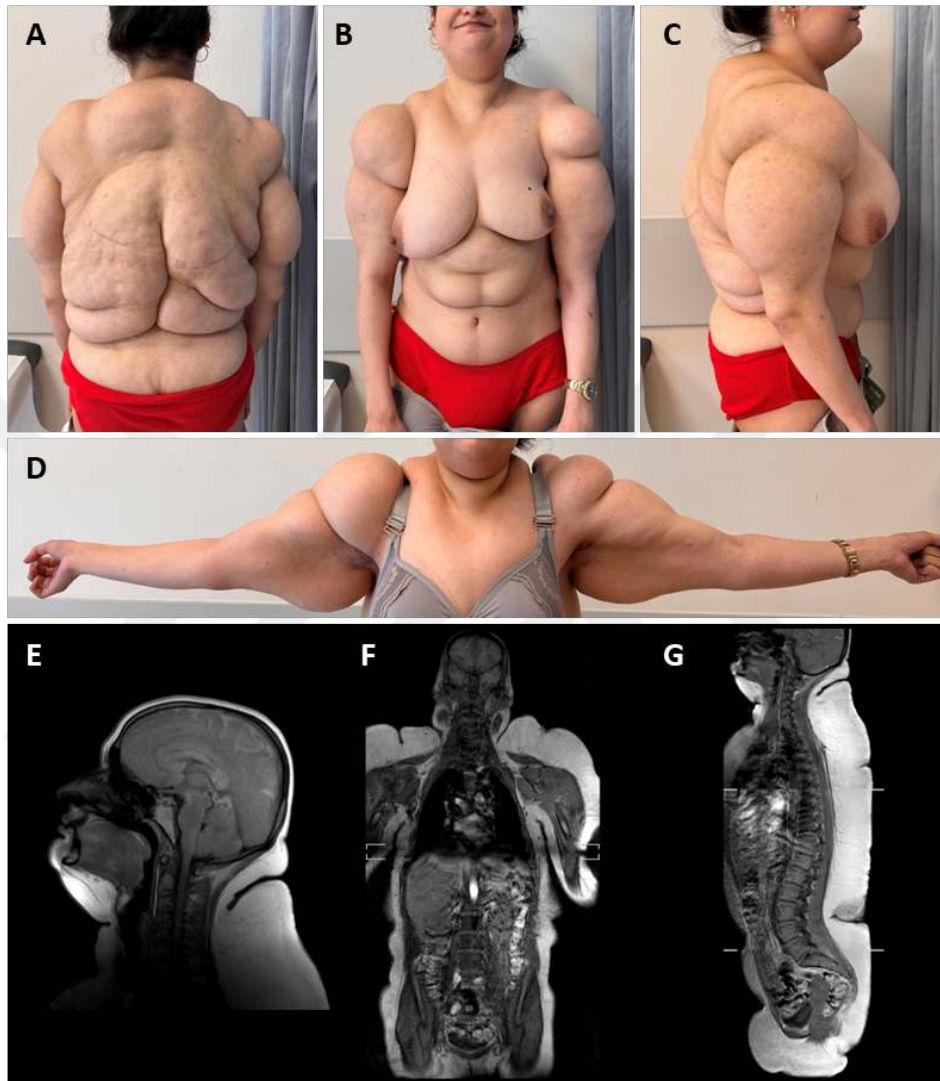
Clinical images of index 7 showing (A-D) symmetric excess lipomatous tissue extending from the neck, upper arms, trunk, back, and mons pubis. (E) MRI images confirming the subcutaneous unencapsulated lipomas with no clear margins.
